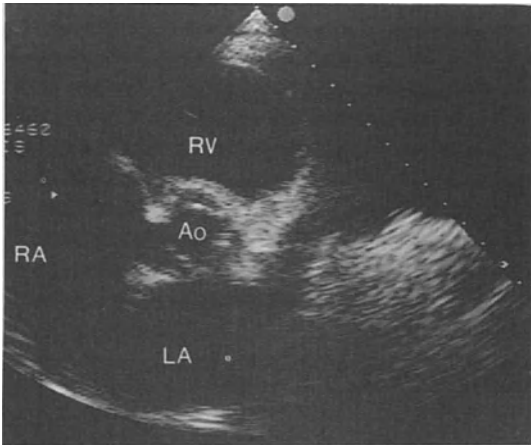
2D Echocardiogram: Short axis view of aortic valve showing three leaflets in open position.
